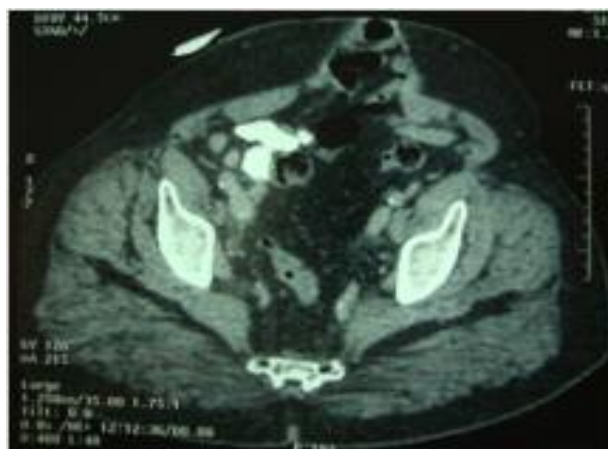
CT scan showing a tumor in the left lateral wall of the bladder
